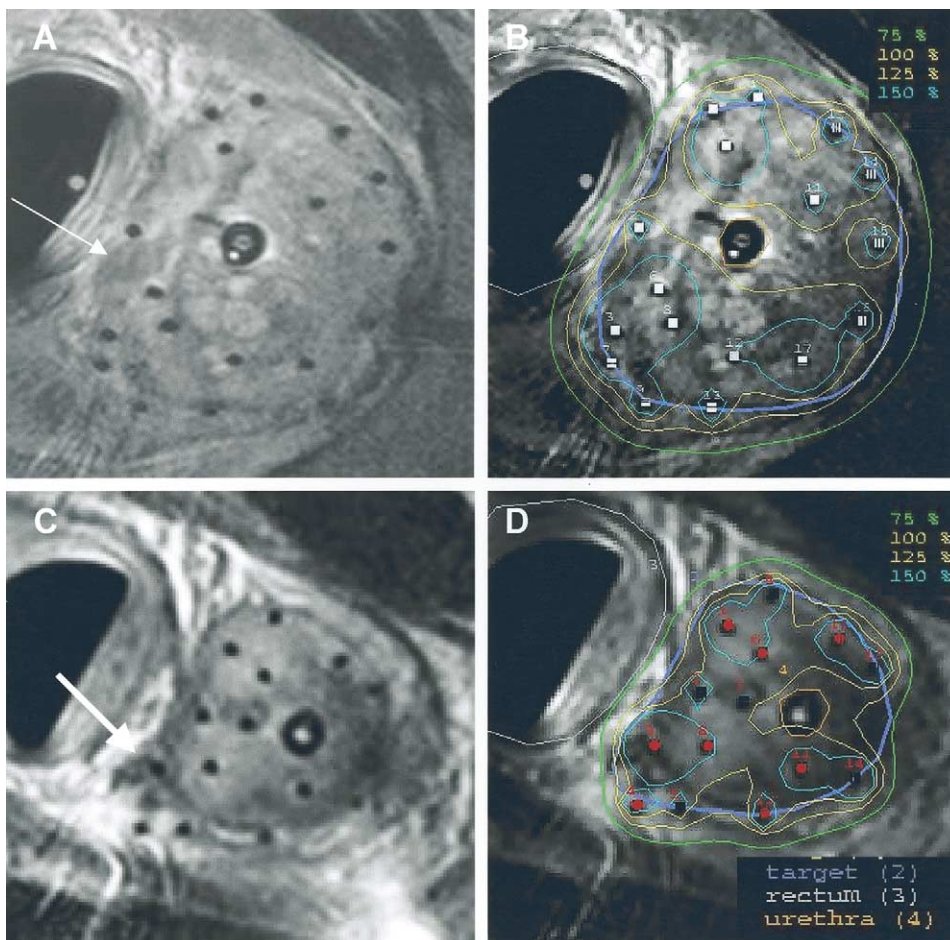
Representative examples of MRI quality obtained to guide catheter placement and for treatment planning. Catheters appear as small black dots (signal void) without creating image artifacts. Areas of low intensity suspicious for malignancy (A, arrow) and extracapsular extension (C, arrow) can be delineated in procedural MRI included in target volume (purple) and encompassed by 100% isodose line (yellow).
